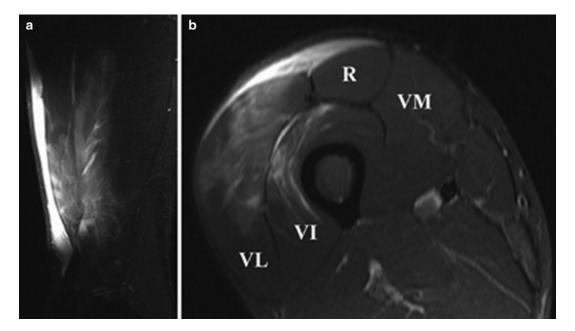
Sagittal and axial STIR sequence MRI of the thigh. The anatomical position of the quadriceps muscle complex on the anterior thigh puts athletes in contact sports at risk for quadriceps contusions, which can be detected on MRI. Sagittal (a) and axial (b) imaging demonstrates a diffuse intramuscular hyperintensity, with epifascial hematoma in the rectus femoris (R), vastus
